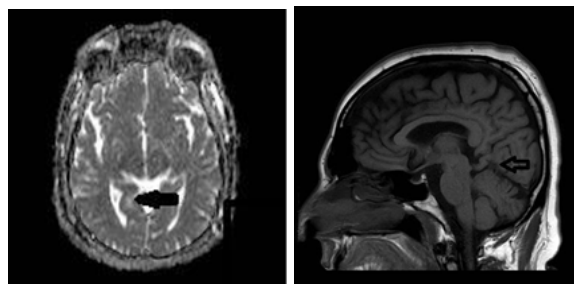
DWI reveals no abnormal restriction. Fig 4.-Sagittal T1WI confirms the findings.
